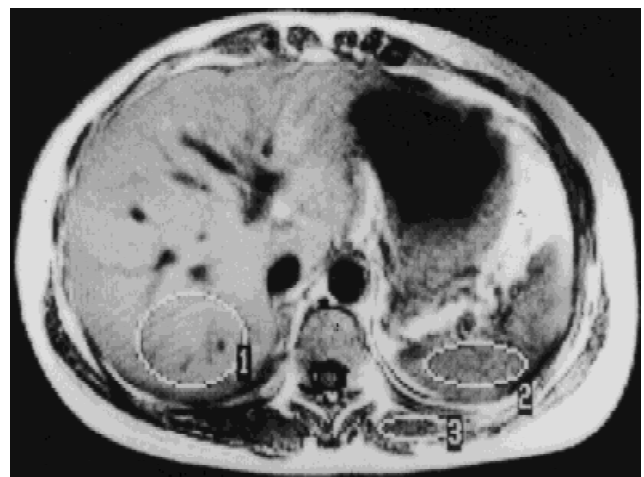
Transverse MR image from T1-weighted spin-echo method. ROI with the numbers 1–3 are placed in the liver, spleen, and muscle, respectively.
